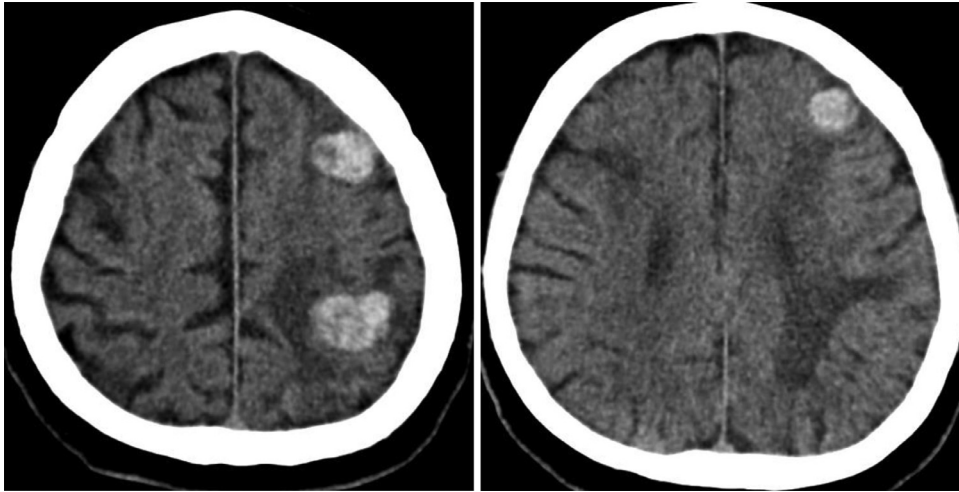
(A-B) Simple brain computed tomography (axial) with multiple hyperdense lesions well defined, subcortical in location with moderate vasogenic edema surrounding them.
